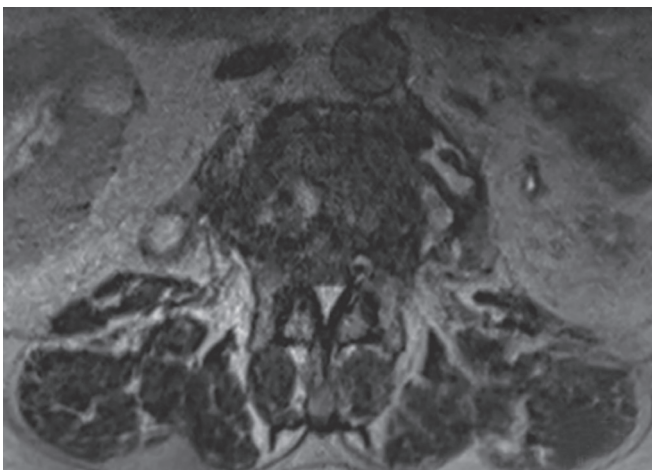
MRI axial image showing Epiduracollection showing spinal cord compression
